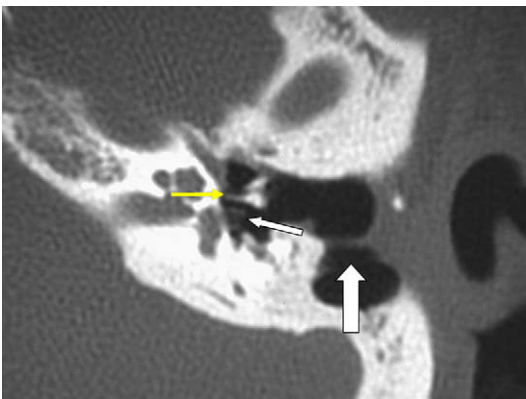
Axial CT in a patient following open mastoidectomy and tympanoplasty. Note that the incus interposition (*yellow arrow*) no longer articulates with the stapes capitulum (*thin white arrow*). There is a web-like closure of the posterior canal defect from scarring (*thick white arrow*).
